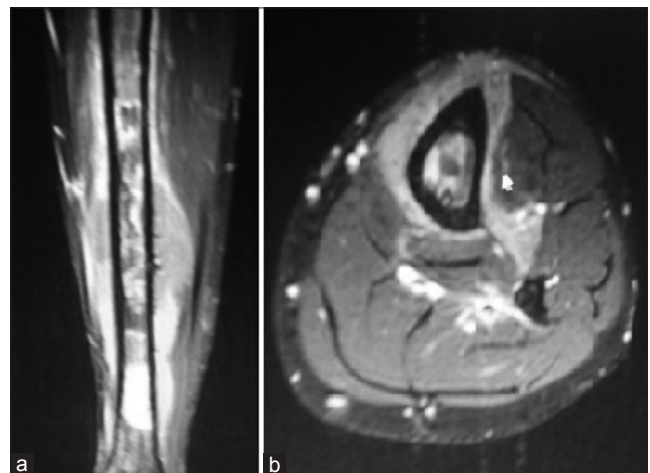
(a) Magnetic resonance imaging contrast study (coronal image) showing altered signal intensity and irregular patchy enhancement lesion involving the marrow of the diaphysis of the tibia. (b) The sagittal image showing diffuse marrow and soft tissue involvement with posterior cortical irregularity
